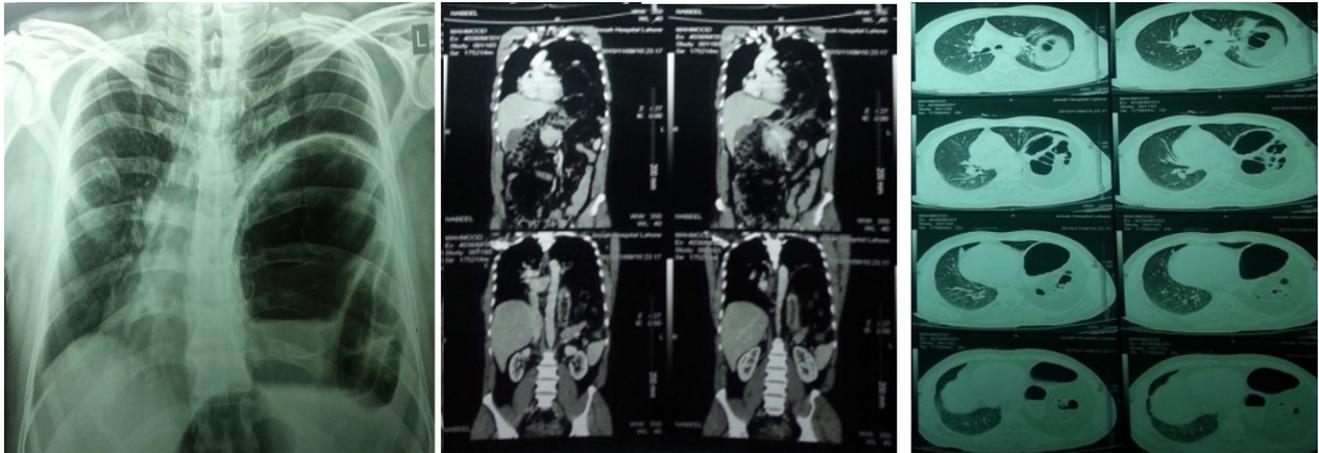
X-ray Chest and CT scan showing eventration of diaphragm. The affected hemidiaphragm is elevated in the shown chest X-ray with regular contours and no blunting of costophrenic angles. Atelectasis, mediastinal deviation, and bowel loops can be observed.
